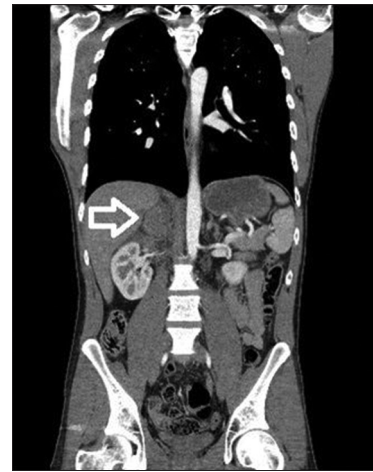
Right adrenal hematoma depicted in CE-CT scan, 2 hours after presentation in the Emergency Department (arrow)
